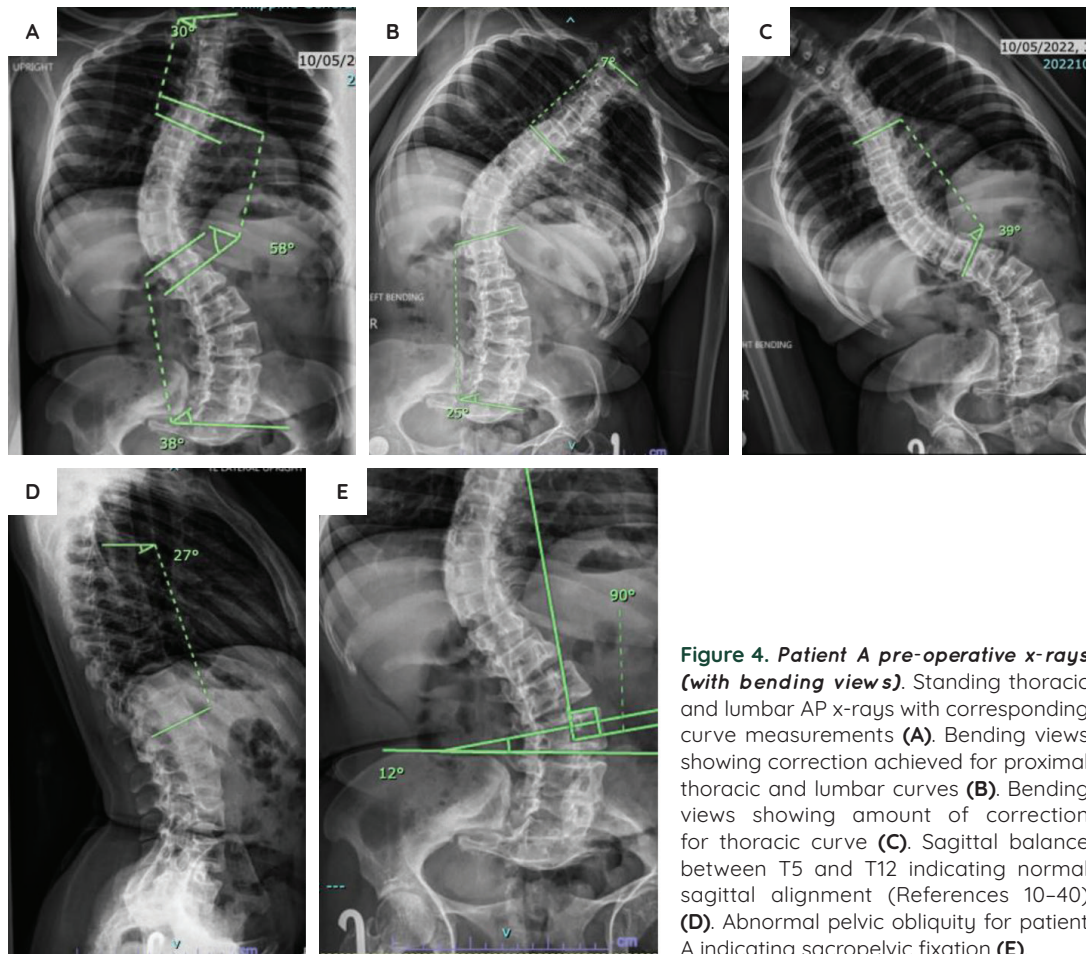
Patient A pre-operative x-rays (with bending views). Standing thoracic and lumbar AP x-rays with corresponding curve measurements (A). Bending views showing correction achieved for proximal thoracic and lumbar curves (B). Bending views showing amount of correction for thoracic curve (C). Sagittal balance between T5 and T12 indicating normal sagittal alignment (References 10–40) (D). Abnormal pelvic obliquity for patient A indicating sacropelvic fixation (E).
